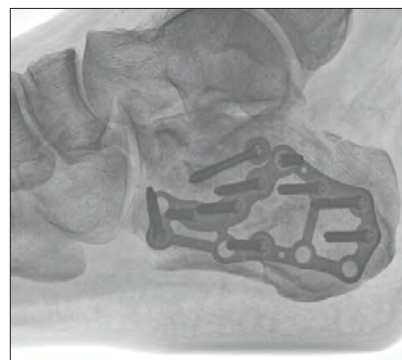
Final intra-op left lateral X-ray
